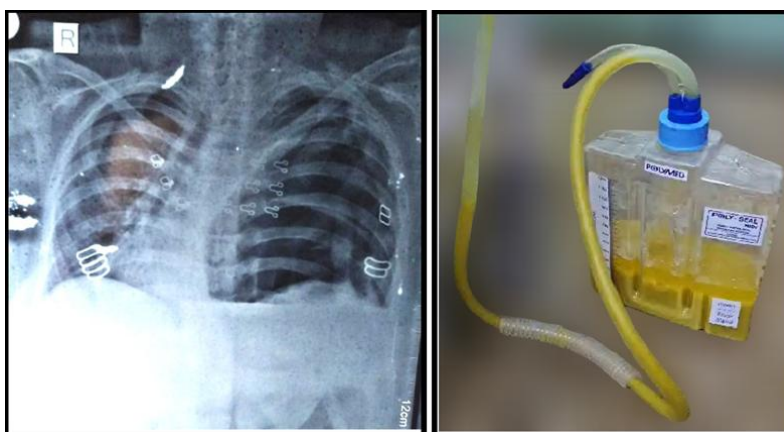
(A): Chest radiography showing tension pneumothorax with mediastinal shift to right. (B): Intercostal drainage tube draining fecal content
